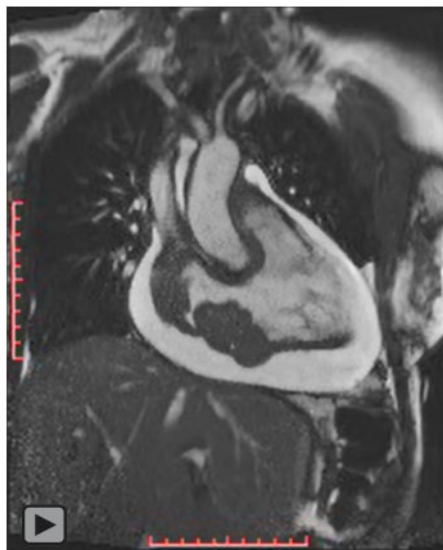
Multimodality imaging of a primary cardiac lymphoma. (A) Chest X-ray. (B) Transthoracic echocardiography—right ventricle view. (C) Contrast-enhanced computed tomography scan of the mass; cardiac magnetic resonance flow mapping. (D and E) Magnitude and velocity encoded image showing great vessel anatomy and a caudal flow in the azygos vein (yellow arrow) similar to the descending aorta flow (red arrow) suggestive of superior vena cava obstruction. (F) Cardiac magnetic resonance steady-state free precession imaging of the mass. (G) Steady-state free precession imaging of the mass and coronary artery encasement. (H) High signal of the mass on T2-short tau inversion recovery by cardiac magnetic resonance. (I) Late gadolinium enhancement imaging of the mass. (J) Highly increased ^{18}F -fluorodeoxyglucose radiotracer uptake by the mass with metabolic tissue volume by positron emission tomography/computed tomography. (K) Follow-up positron emission tomography/computed tomography after six cycles of chemotherapy showing complete remission of the tumour (see also text for details).
